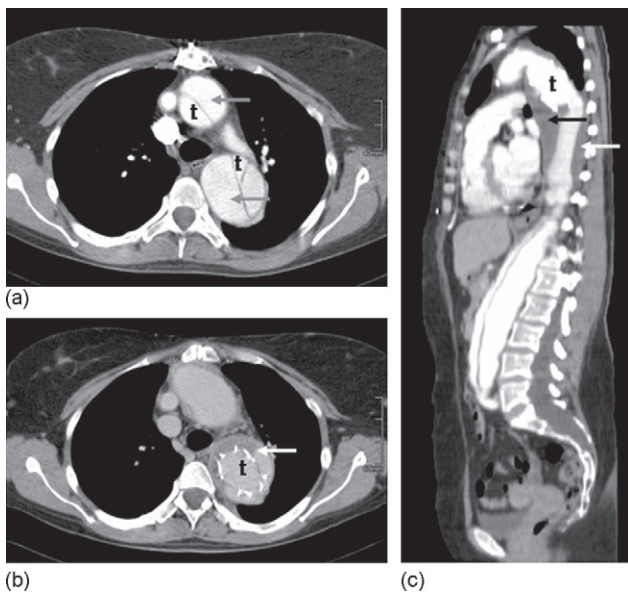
(a) CT scan shows dissection of the distal ascending and descending aorta. Due to the complex dissection the true (t) and false lumen (arrows) is marked. (b and c) Contrast CT-scans show implantation of the hybridprosthesis. The false lumen around the stented segment of the E-vita prosthesis in the descending aorta is thrombosed partially within 9 days.
